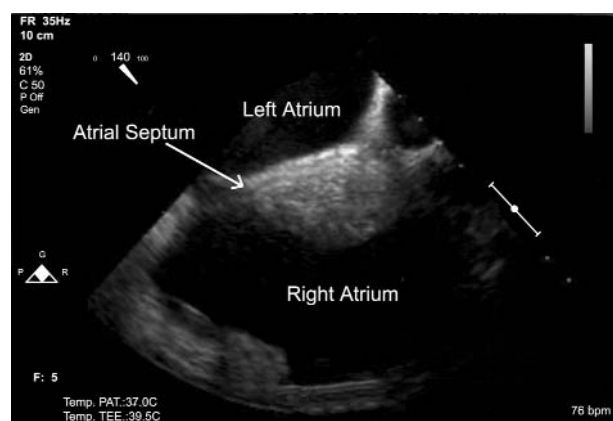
Transoesophageal echocardiographic bicaval view at 114° showing the large amyloid mass infiltrating the interatrial septum
